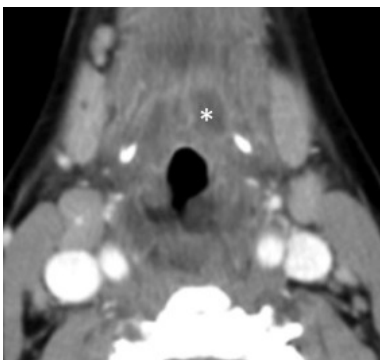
Supraglottic extension. Axial contrast enhanced CT at the level of the supraglottis shows the extension of the inflammation to the floor of the mouth (*) and to the aryepiglottic folds, occluding the pyriform sinus.
